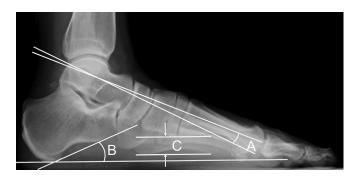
Lateral radiograph showing measurements of A, talo-first metatarsal angle; B, calcaneal pitch angle; and C, medial cuneiform-fifth metatarsal height.
